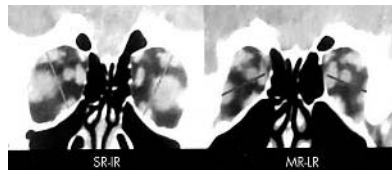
Preoperative coronal views on CT scan of both orbits showing evidence of rectus muscle heterotopy. A vertical line joining the centre of the belly of the vertical rectus muscles shows the relative temporal displacement of the superior rectus muscle compared to the nasal displacement of the inferior rectus muscle. A horizontal line joining the centre of the belly of the horizontal rectus muscles shows the relative inferior displacement of the lateral rectus muscle compared to superior displacement of the medial rectus muscle.
